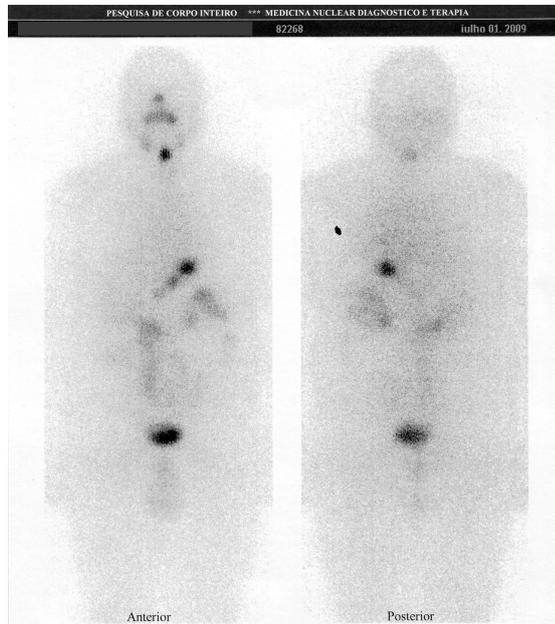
A scintigraphy of the whole body using a gamma camera detector and ^{131}I . The image shows uptake of iodine in the thyroid region due to thyroid cancer. Uptake seen in other regions (mouth, salivary glands, colon, stomach and urinary bladder) are due to normal excretion. The image does not show metastases in other regions. From Ref. [3].
